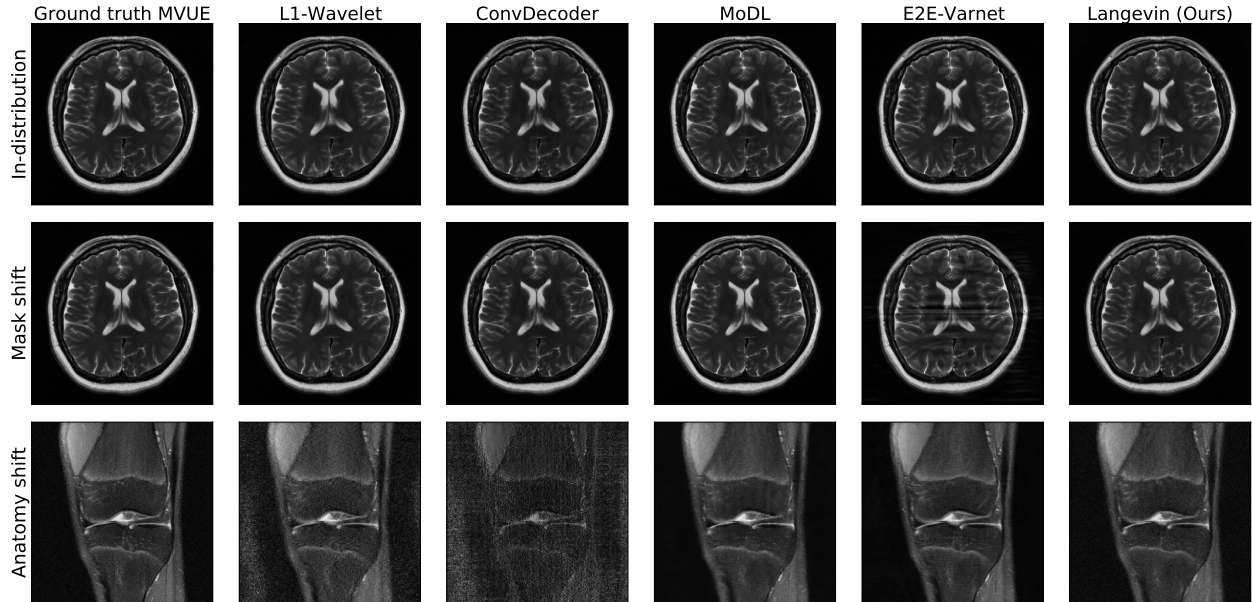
Comparison of reconstruction methods for in-distribution, sampling-shift, and anatomy-shift images. Our generative prior was trained *exclusively* on T2-weighted *brain* scans from the NYU fastMRI dataset, and the training of the generative prior was independent of the measurement model. Observers familiar with reading MR images [90] will notice that our reconstruction is similar in diagnostic value to E2E-Varnet, a supervised state of the art method, when in-distribution and outperforms all competing methods out of distribution. In the latter case, competing methods often introduce artifacts that render them diagnostically unusable. Note that hyperparameters for all methods were chosen for the in-distribution setting and reused under data shifts.
